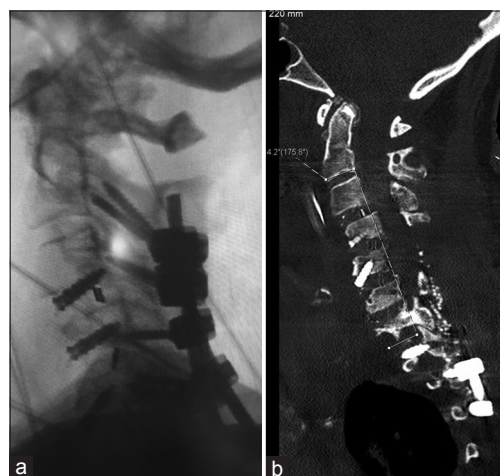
Lateral X-ray (a) and sagittal computed tomography (b) of the cervical spine showing restoration of cervical lordosis and C2–C7 sagittal vertical axis
